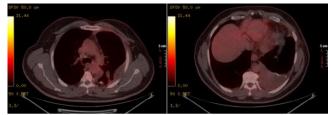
Pathological 18f-FDG uptake observed in areas with pleural thickening and pleural effusion on PET-CT
